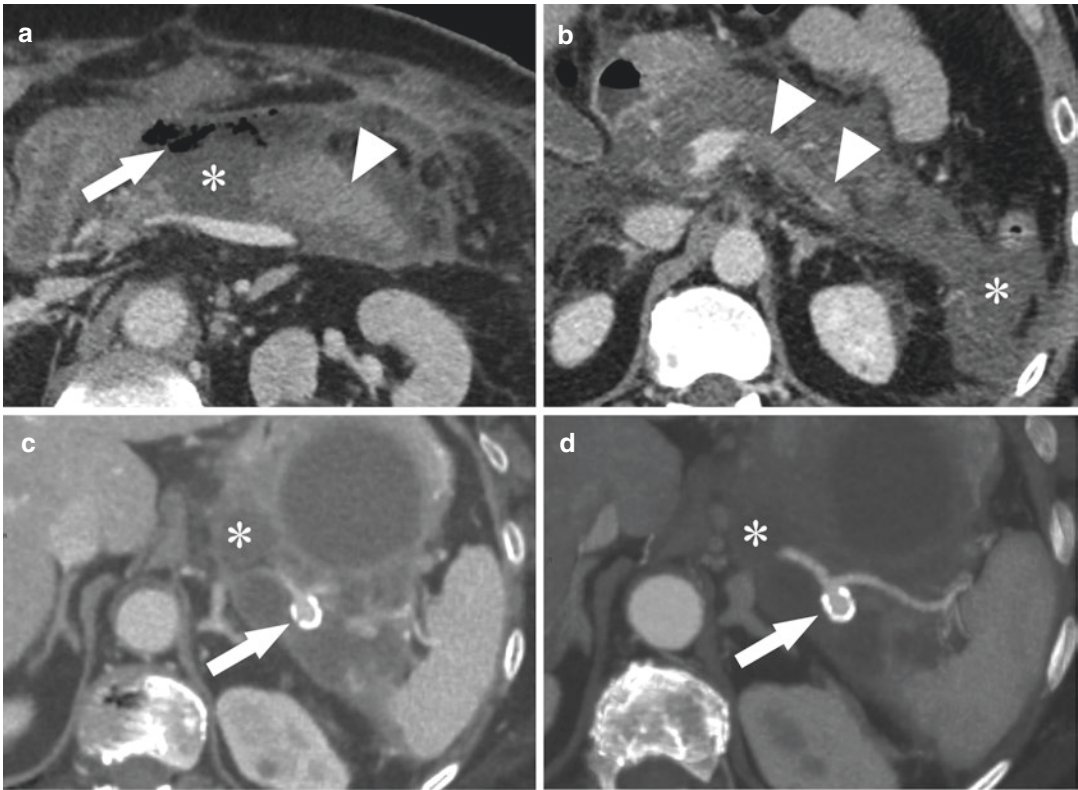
Acute pancreatitis complications. (a) Seventy-two-year-old woman with acute pancreatitis. Axial contrast enhanced portal venous phase CT image shows pancreatic tail (arrowhead) and multiple gas foci (arrow) within a heterogeneous fluid attenuating peripancreatic collection (*) with thick enhancing walls. These findings are suggestive of infected WON. (b) Sixty-four-year-old man with acute pancreatitis. Axial contrast enhanced portal venous phase CT image shows a hypodense thrombus within the splenic vein (arrowheads).
